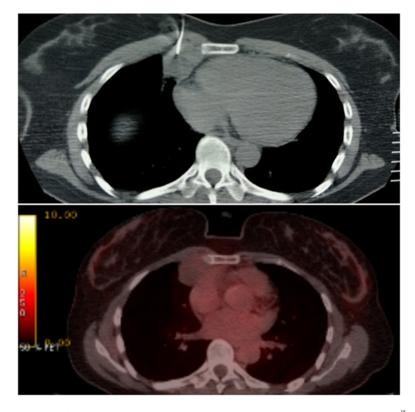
True-positive 18F-FDG uptake. A 62-year-old male presented with a large anterior mediastinal mass. A pre biopsy PET/CT was available delineating the areas with  $the highest \, metabolic \, activity. \, The \, 16/9 \, G \, needle \, was \, placed \, in \, the \, most \, solid \, area \, with \, the \, highest \, metabolic \, activity. \, The \, result \, of \, the \, biopsy \, was \, Hodgkin \, lymphoma.$
